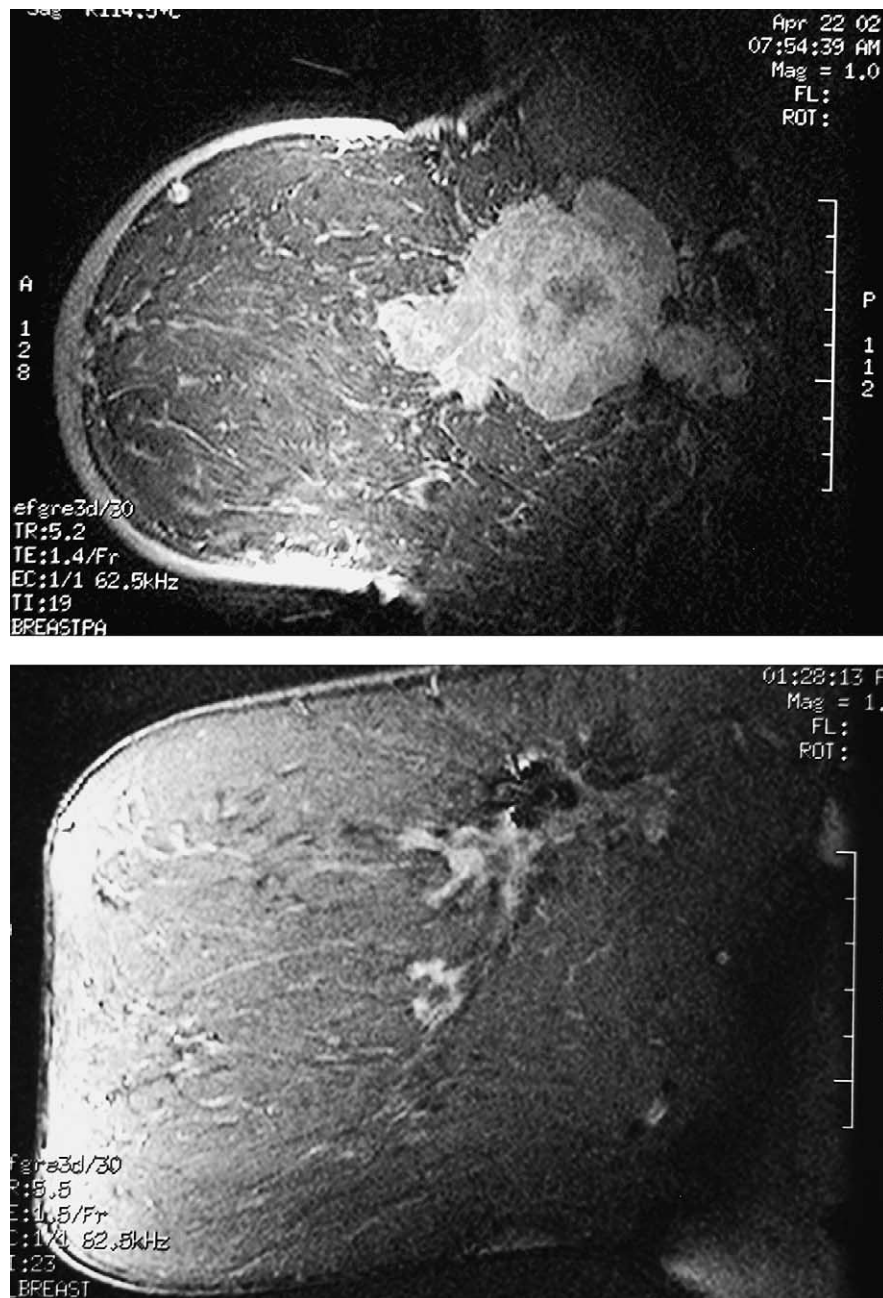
Breast MRI taken at diagnosis and after 4 months neoadjuvant therapy with letrozole 2.5 mg daily. The patient's surgical outcome improved from inoperable to successful mastectomy with negative surgical margins. Note the resolution of breast skin thickening, a sign of inflammatory breast cancer.
